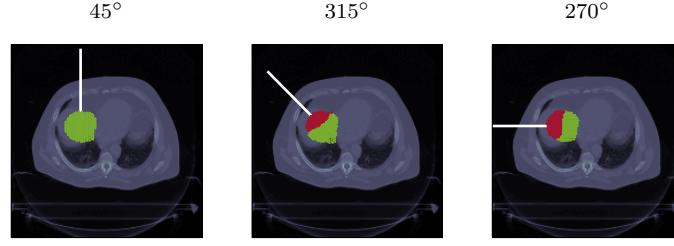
Axial CT slice for the liver patient with different beam angles. The overlay highlights the spots in green (●) with sufficiently large residual helium range and the ones with insufficient residual helium range in red (●).
